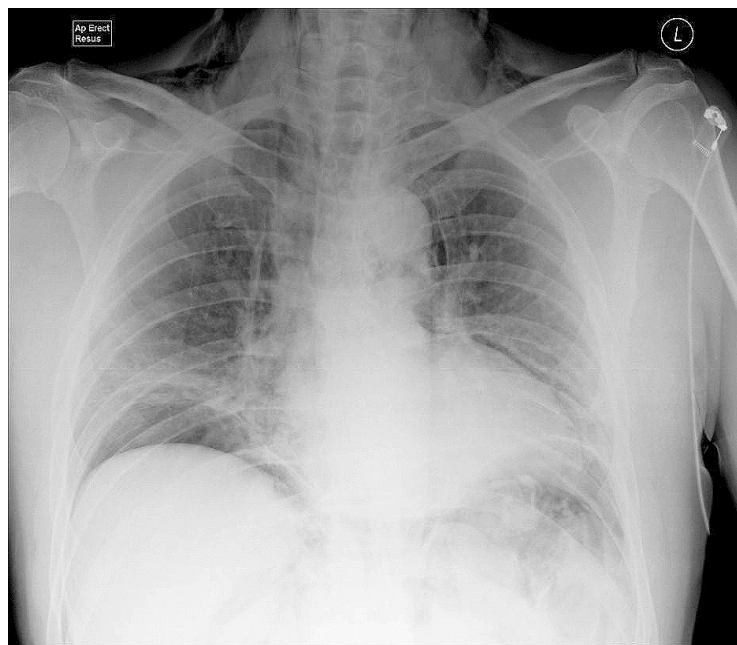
Erect Chest x-ray on admission to the Emergency Department. Free air is most noticeable under the right hemidiaphragm and along the left heart and aorta. Surgical emphysema is evident throughout the soft tissues of the neck
